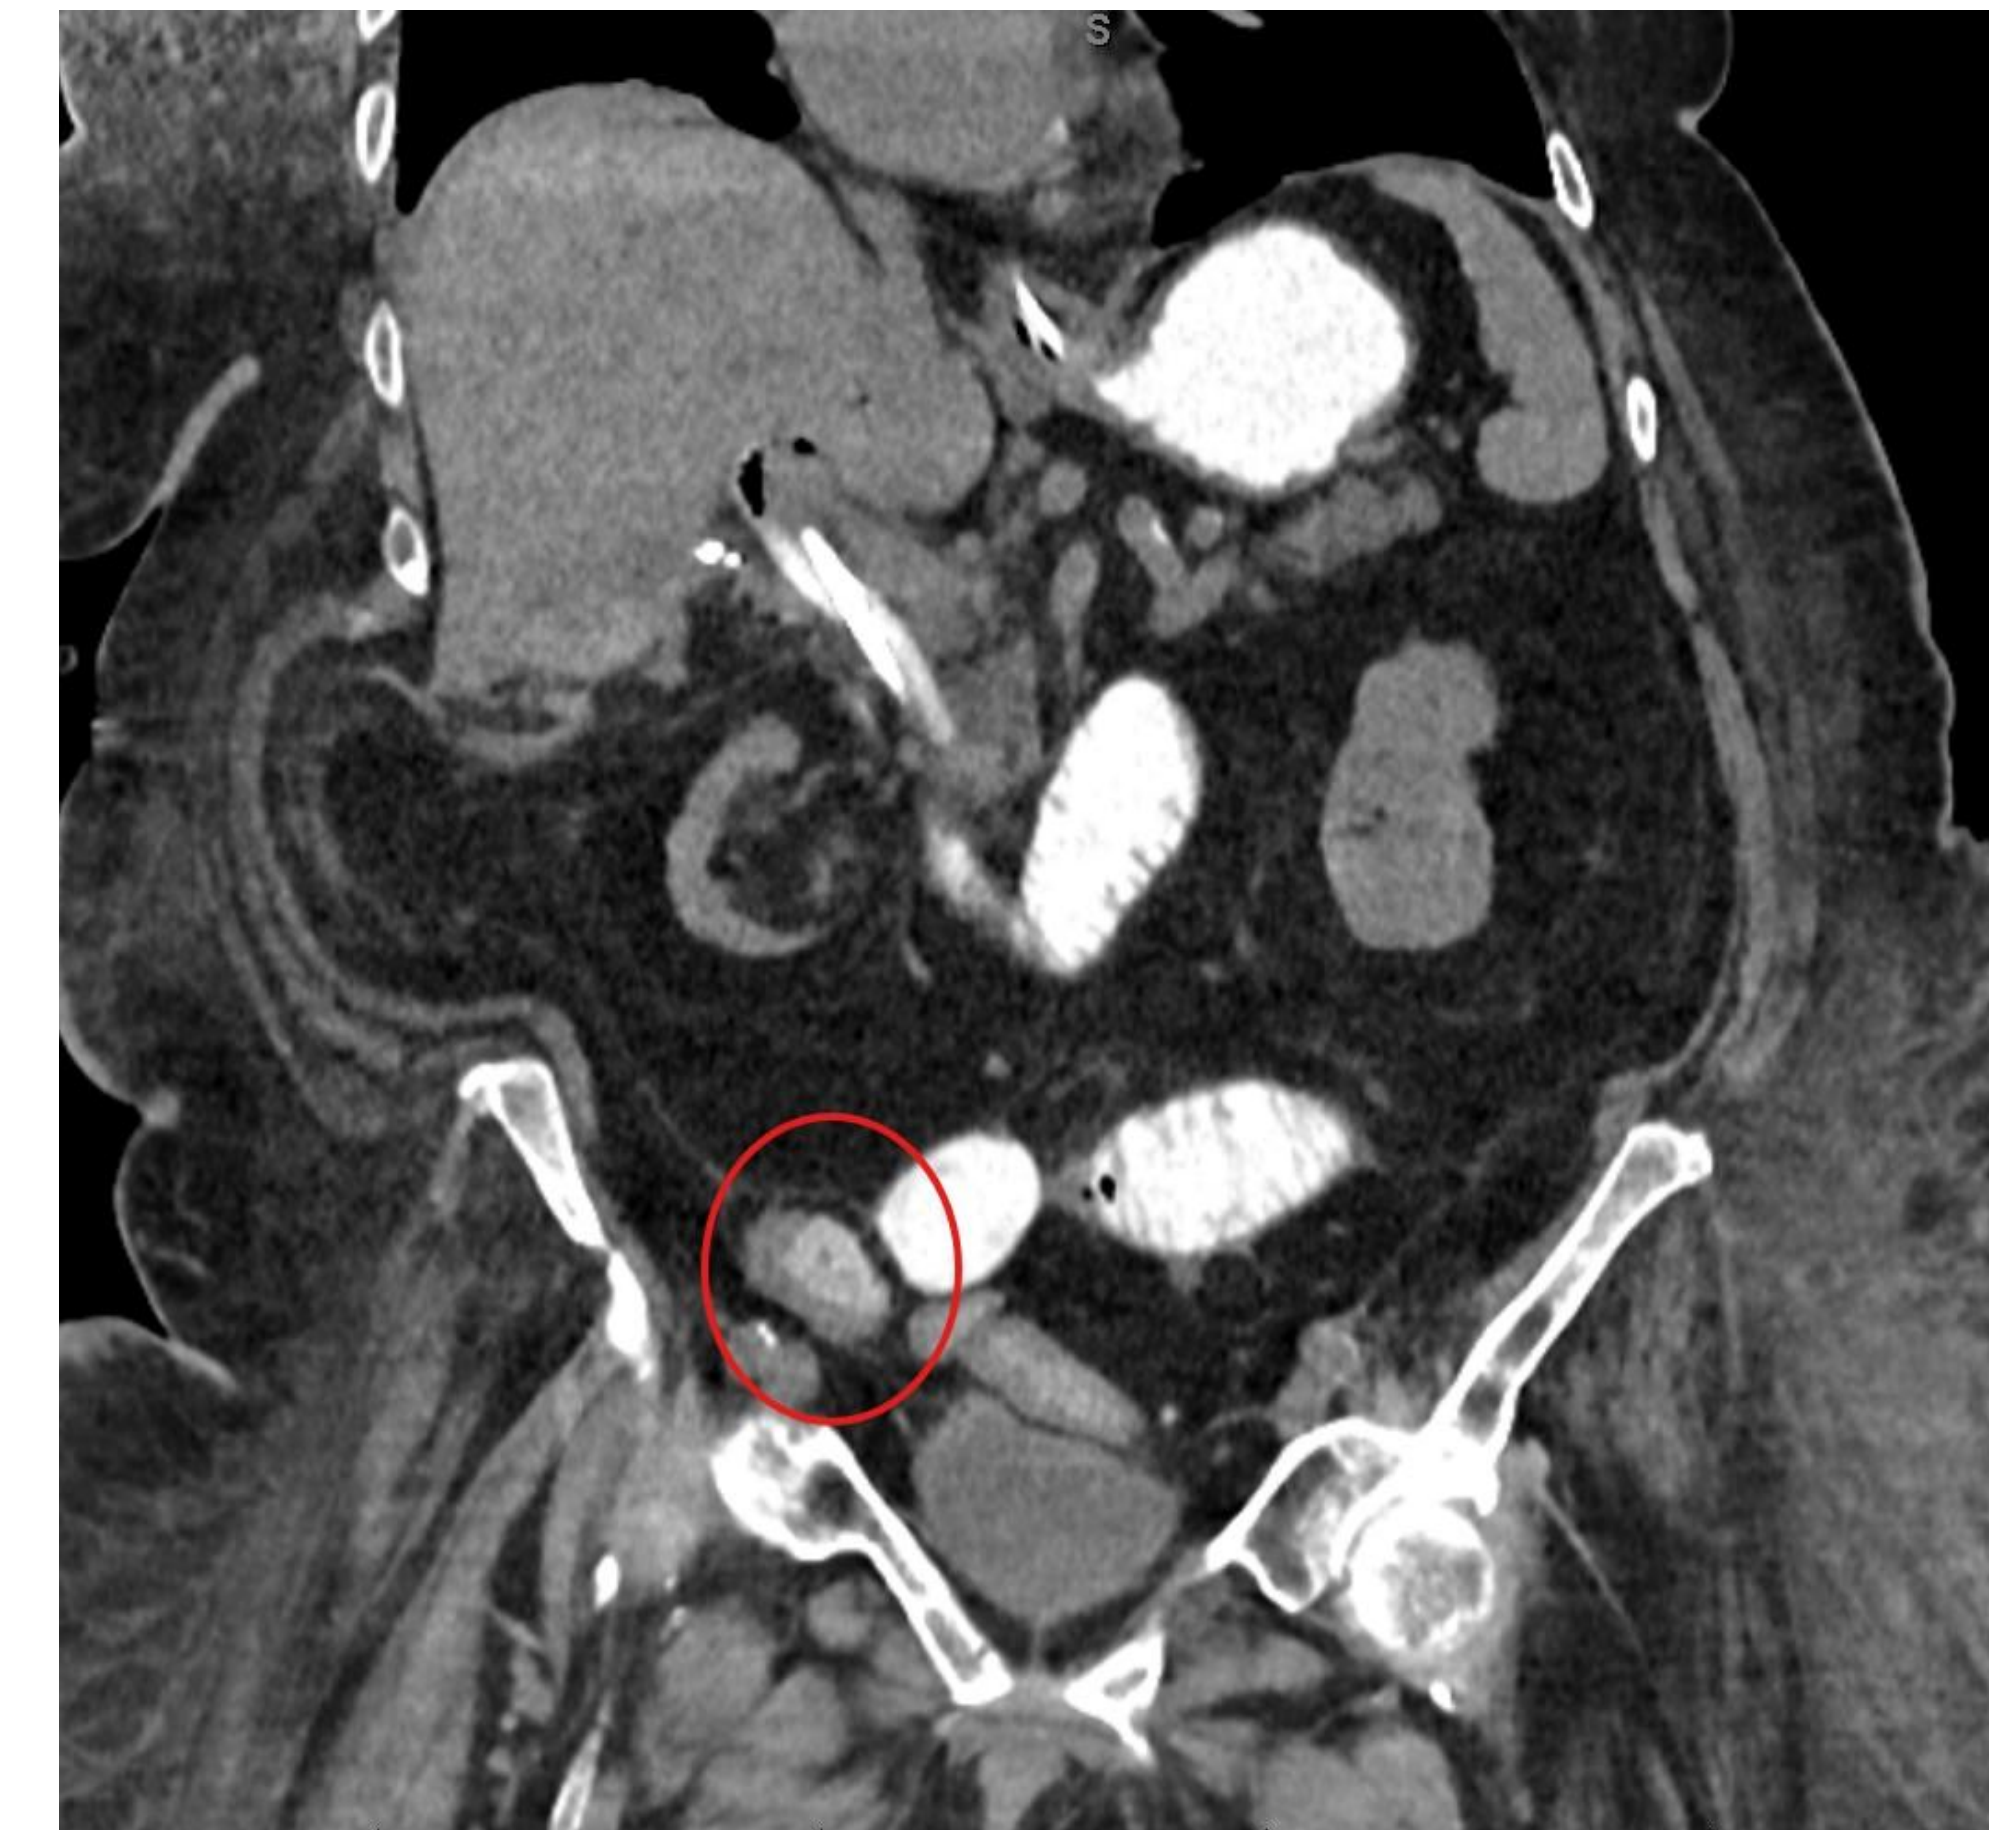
Post ERCP CT showing gallstone ileus with proximal bowel dilation.
